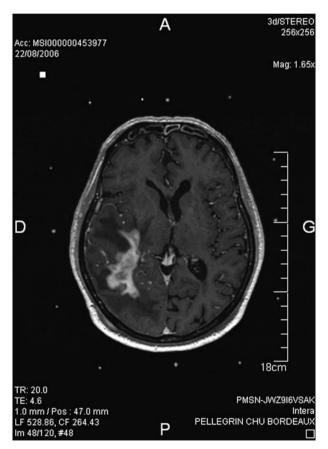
Typical pattern: homogeneous periventricular enhancement on T1-weighted sequences after IV Gadolinium infusion
